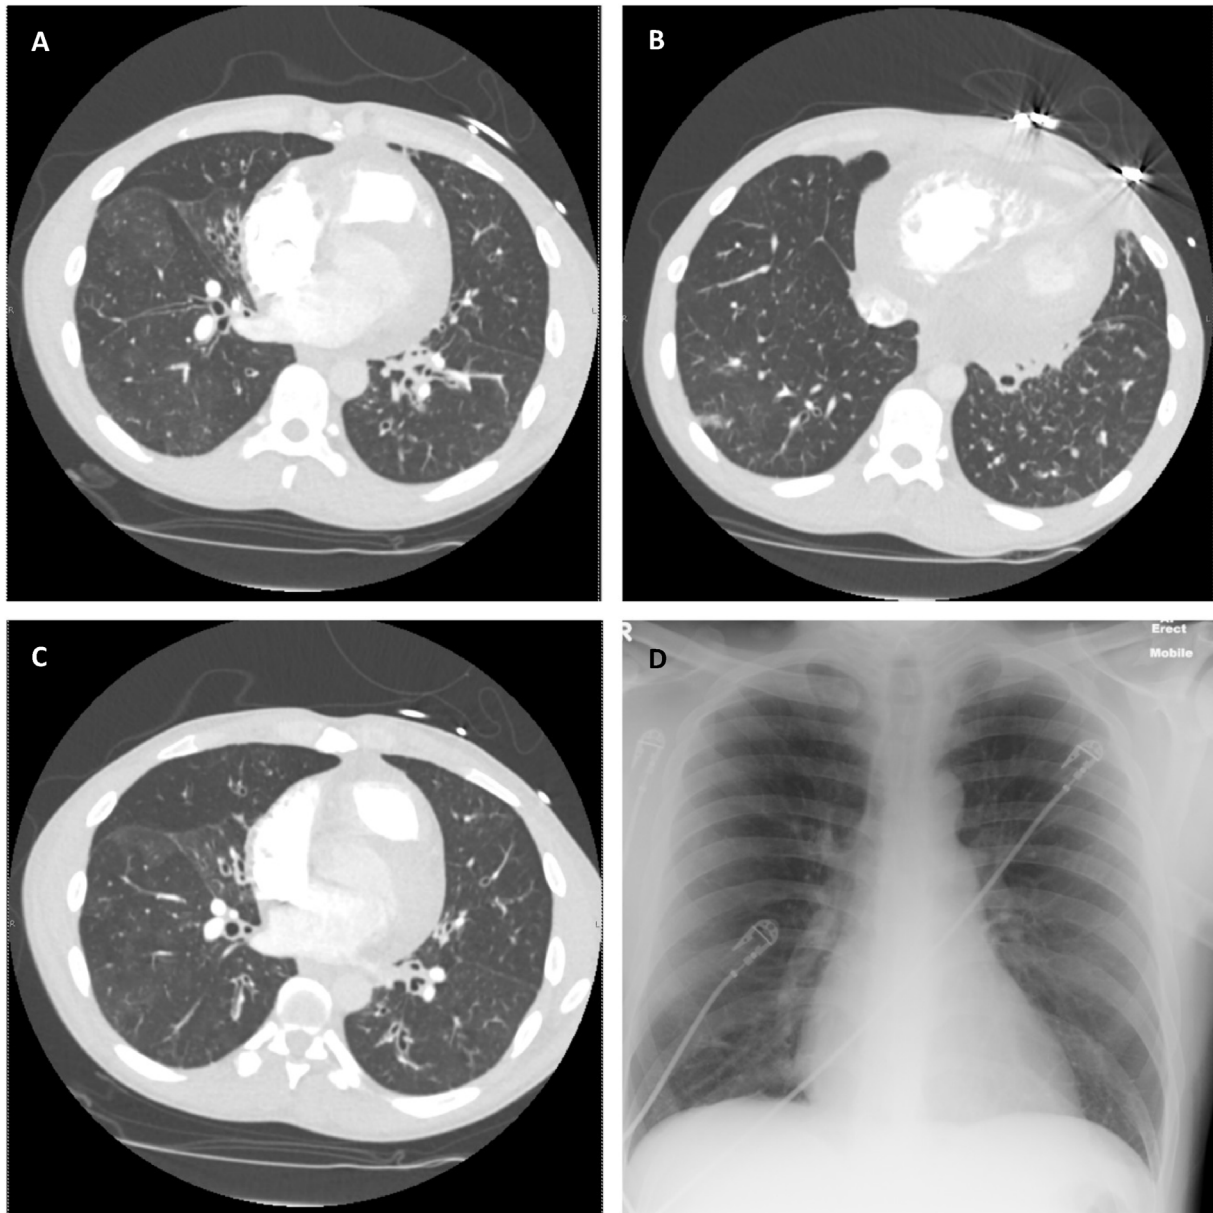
A, B, C: CT chest showing centrilobular nodules, patchy ground glass opacity, thickening of bronchovascular bundles and bibasal bronchiectasis. D: Bilateral pulmonary micronodules.
